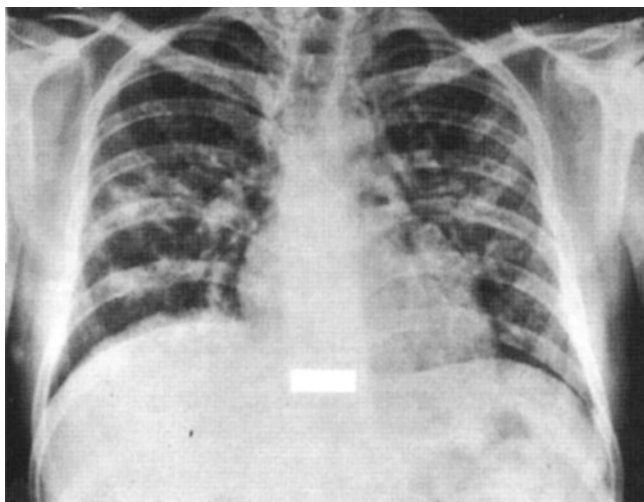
Chest radiograph showing a diffuse mixed alveolar/interstitial pneumonitis due to cytomegalovirus
